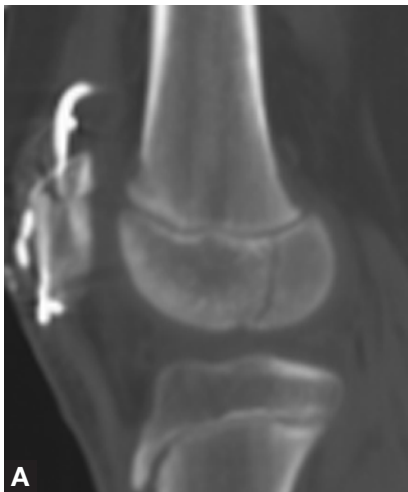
Case 1—Computed tomography (CT) scan of undisplaced coronal plane Salter III fracture of the lateral femoral condyle. There is no significant metal artifact, despite the presence of hardware for the patella fracture.
